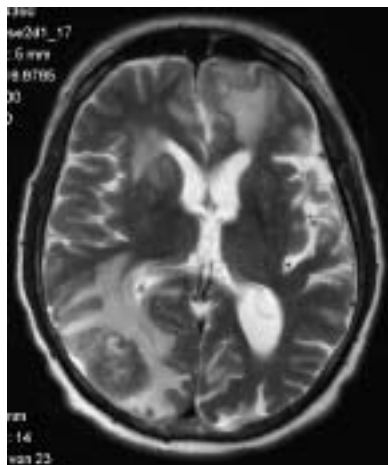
Axial T2-weighted MR image showing the typical aspect of edema in cerebral metastases in a patient with pulmonary carcinoma.
